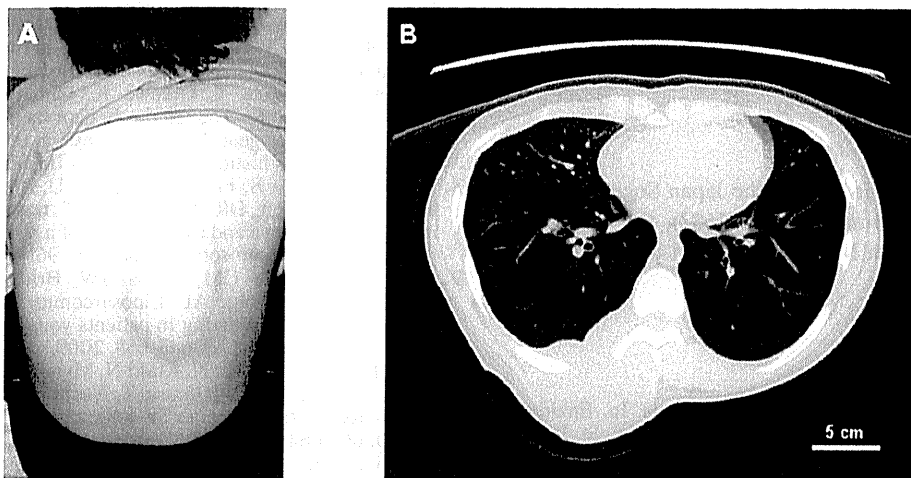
(A) Clinical image of case 4. A large mass located in the right section of the back. (B) Computed tomography image demonstrating the lesion mostly localized in the back muscle, partly penetrating into the thorax.
